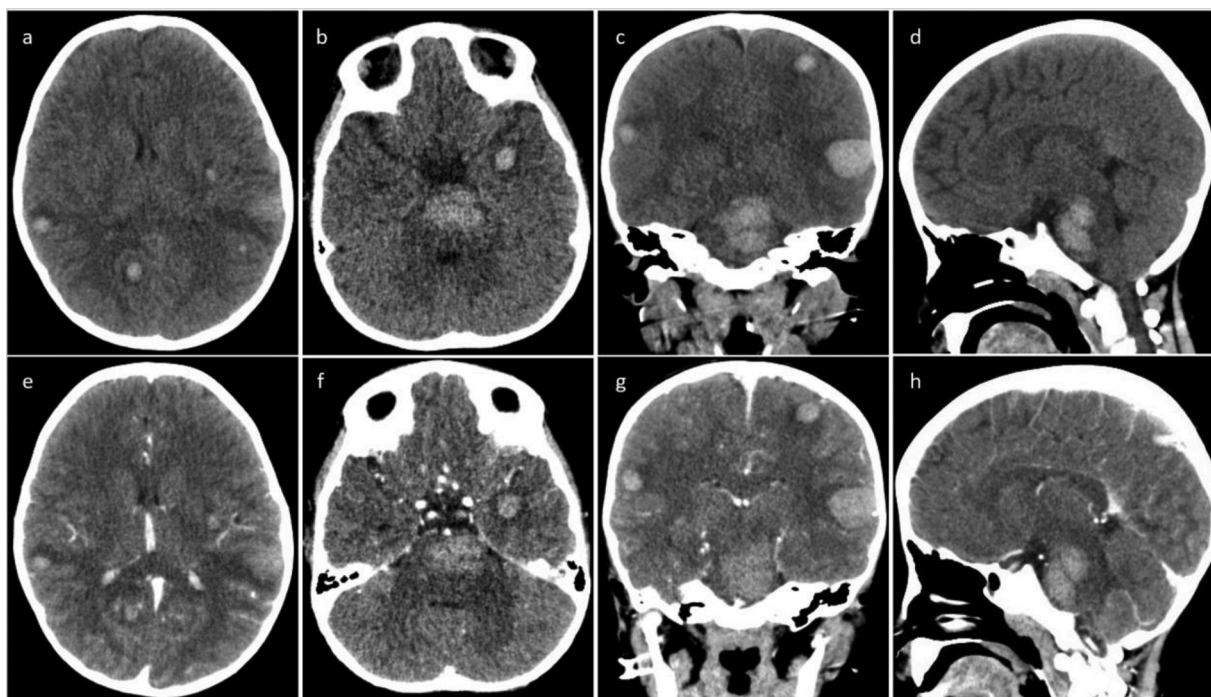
Non-contrast (a–d) and contrast (e–h) head CT in axial (a–b, e–f), coronal (c,g) and sagittal (d,h) view showed multiple, non-enhancing hyperdense lesion with smooth margins, various sizes in cerebral parenchyma, especially left cerebral hemisphere, as well as in mid-brain and pons. Thin perifocal oedema was noted. Density of the lesions were 55–70 HU. Diffuse cerebral oedema was present.
